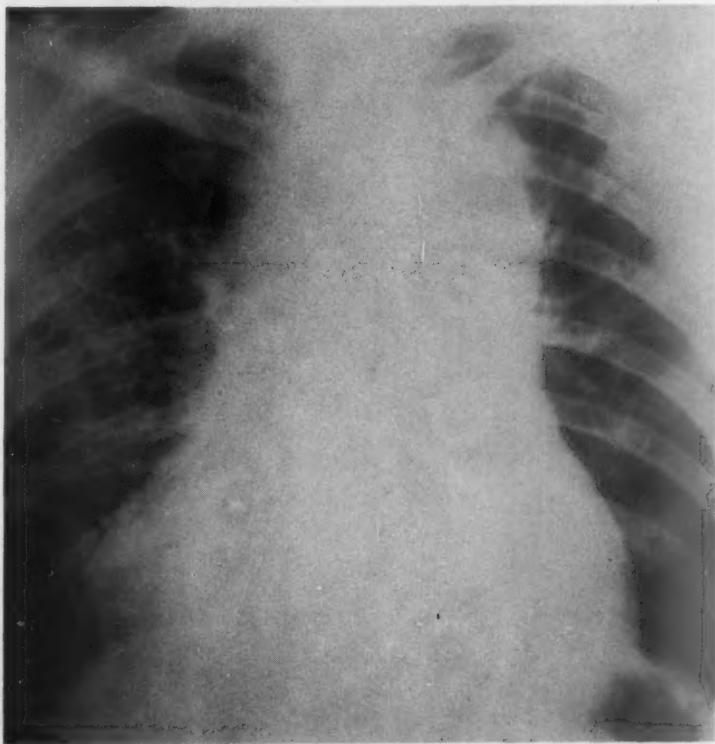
This is the posterior-anterior chest roentgenogram of a 26 year old white man admitted with substernal pain aggravated by exercise, and palpitation and dyspnea on exertion. The physical examination showed substernal dullness and a pericardial friction rub. The film of the chest shows a massive tumor projecting into both the right and the left chests. No nodes were found. A scalene node biopsy gave definite evidence of lymphoblastoma.
